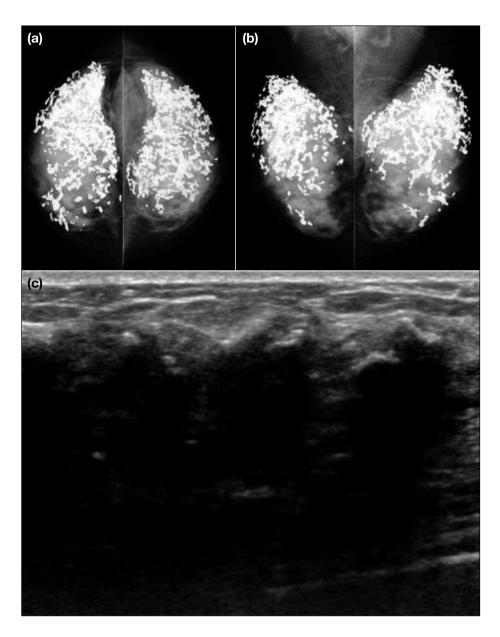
Imaging findings of a patient with lupus mastitis. (a, b) Craniocaudal (a) and mediolateral oblique (b) mammograms showing extensive coarse calcifications of both breasts. (c) Ultrasonogram showing diffuse coarse calcifications of both breasts.
